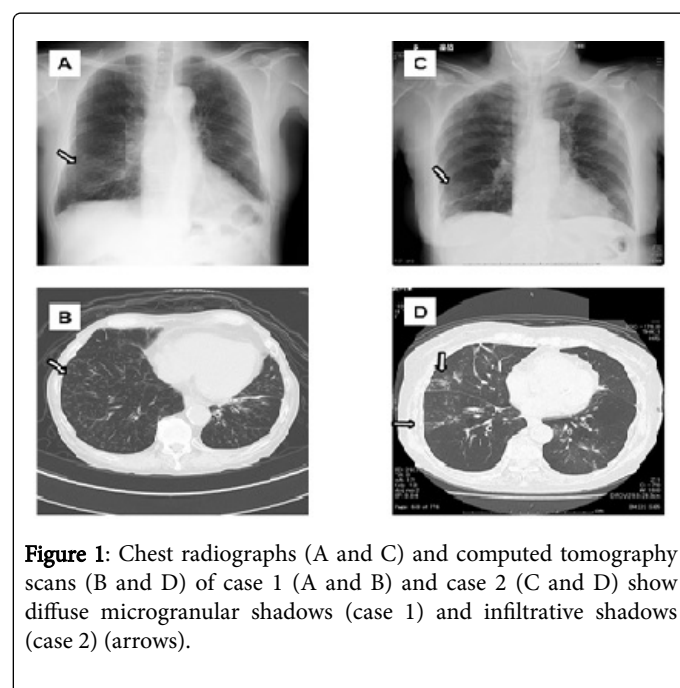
Chest radiographs (A and C) and computed tomography scans (B and D) of case 1 (A and B) and case 2 (C and D) show diffuse microgranular shadows (case 1) and infiltrative shadows (case 2) (arrows).
